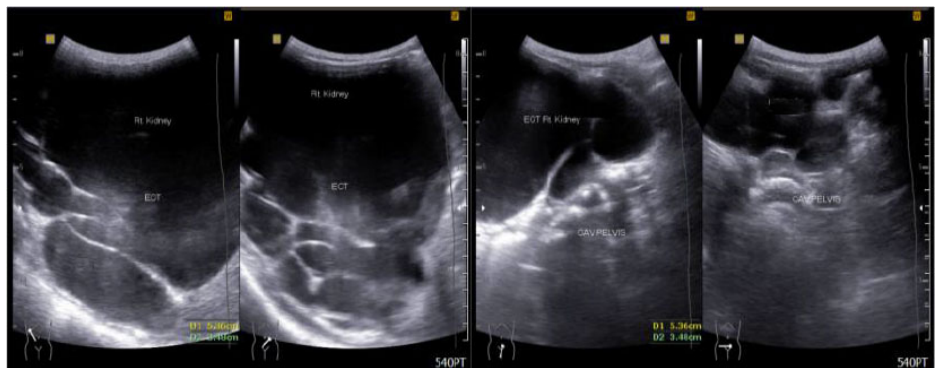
Ultrasound revealed severe hydroureteronephrosis on right kidney.
